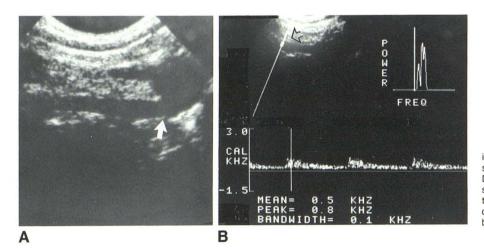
A, The normal vertebral real-time image is demonstrated in an angiographically normal vessel. Vertebral origin (*arrow*) is well seen. B, Normal Doppler waveform of vertebral artery has flow in systole and in diastole, and is similar in waveform to that of internal carotid artery. The angle of incidence between Doppler beam and direction of blood flow should be 30–60° (*open arrow*).
